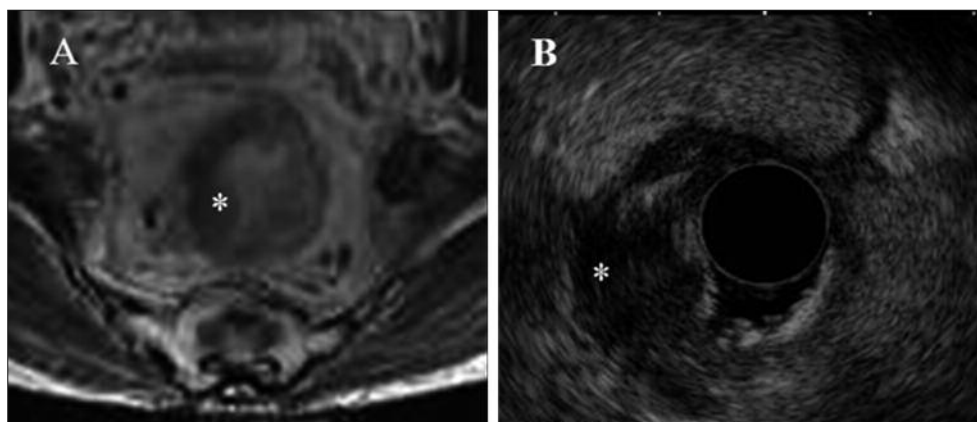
T3 malignant tumor stranding in MRI and EUS. T3 tumor located in the left side that penetrated the rectal wall and invaded perirectal fat (*). A, MRI view, showed more details. B, EUS view.
